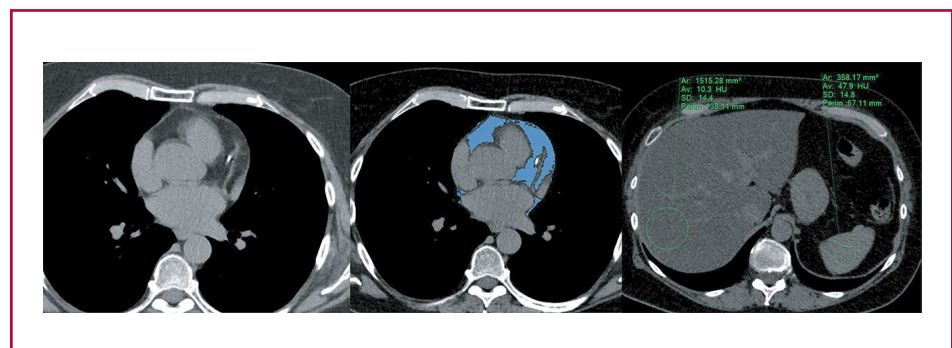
Quantification of epicardial fat, assessment of coronary artery calcification and identification of hepatic steatosis by conventional chest CT scan. Notice the presence of calcification at the level of the anterior descending artery, with increased epicardial fat volume (in blue) and severe hepatic steatosis (10 HU and 0.21 liver/spleen ratio).
